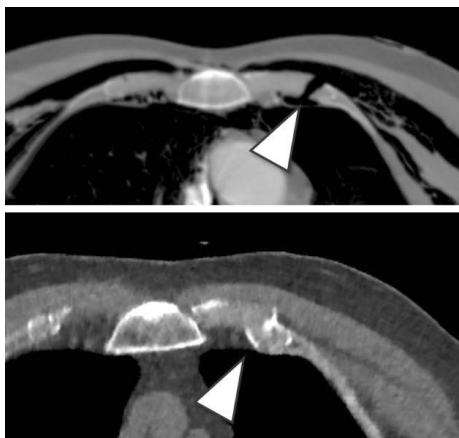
64-year-old male, compression accident. Upper image: axial image from initial trauma CT shows a CCFX of left 2nd rib with diastasis (arrowhead). Lower image: follow-up ULD-CT image of the same CCFX 4 years and 10 months later, reveals dislocation and calcification (arrowhead). The fracture was assessed stable both radiologically and on clinical examination.
